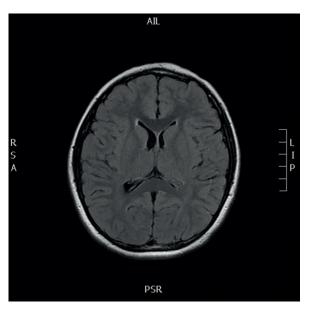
Brain MRI axial flair image showing mild generalized atrophy.
